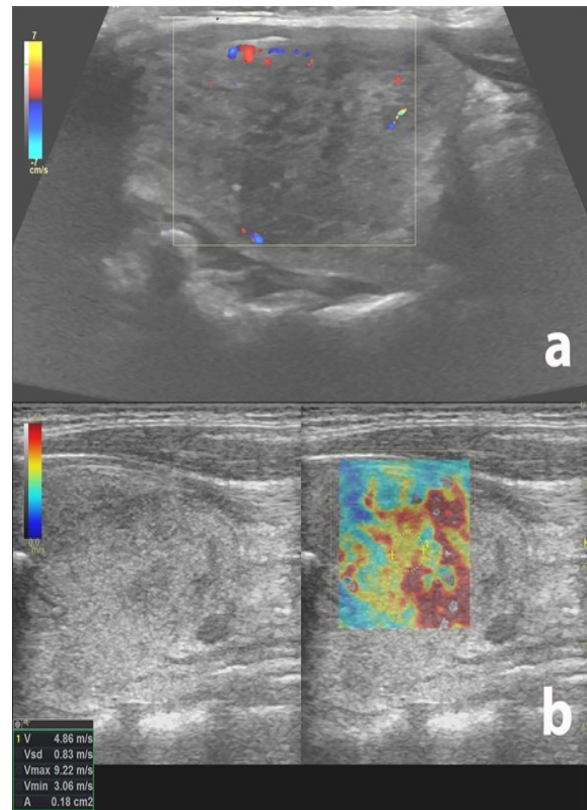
Doppler and elastography examination of the thyroid gland parenchyma. a) Hypovascularity of the same thyroid tissue in color Doppler sonography; b) Parenchymal patchy heterogeneity and increased stiffness in elastographic examination.
